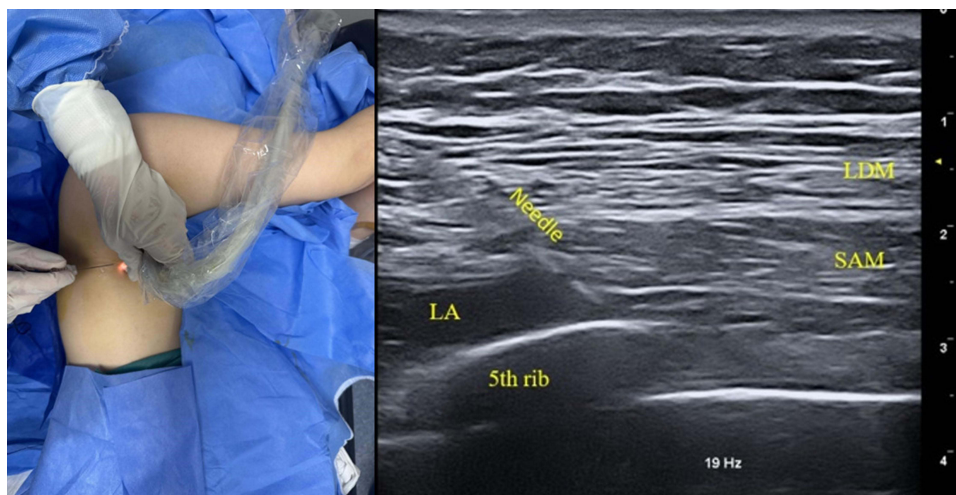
Ultrasound image of SAPB application.
